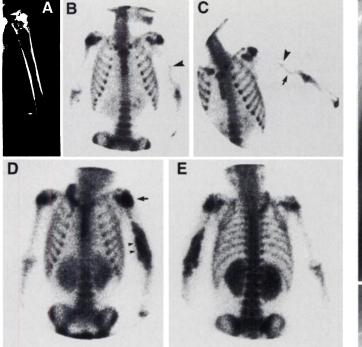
(A) Radiograph of the left humerus demonstrates minimal periosteal reaction (arrow). Postoperative bone defects and gas in the soft tissues are present. (B) Anterior and (C) oblique delayed views demonstrate absent uptake in the left humeral shaft except for a small focus in the midshaft (arrowhead). Linear radiotracer (arrow) outside the expected humeral contour represents activity in elevated periosteum. There is improved but persistently decreased uptake in the proximal physis. (D) Anterior and (E) posterior delayed images demonstrate increased activity in the proximal physis and epiphysis (arrow); radiotracer intensity obscures their distinction. Distally increased activity extends beyond the expected cortex (arrowheads), indicating exuberant periosteal reaction. A short segment of the diaphysis remains photopenic. There is radiotracer retention in the central intravenous line used for injection.
